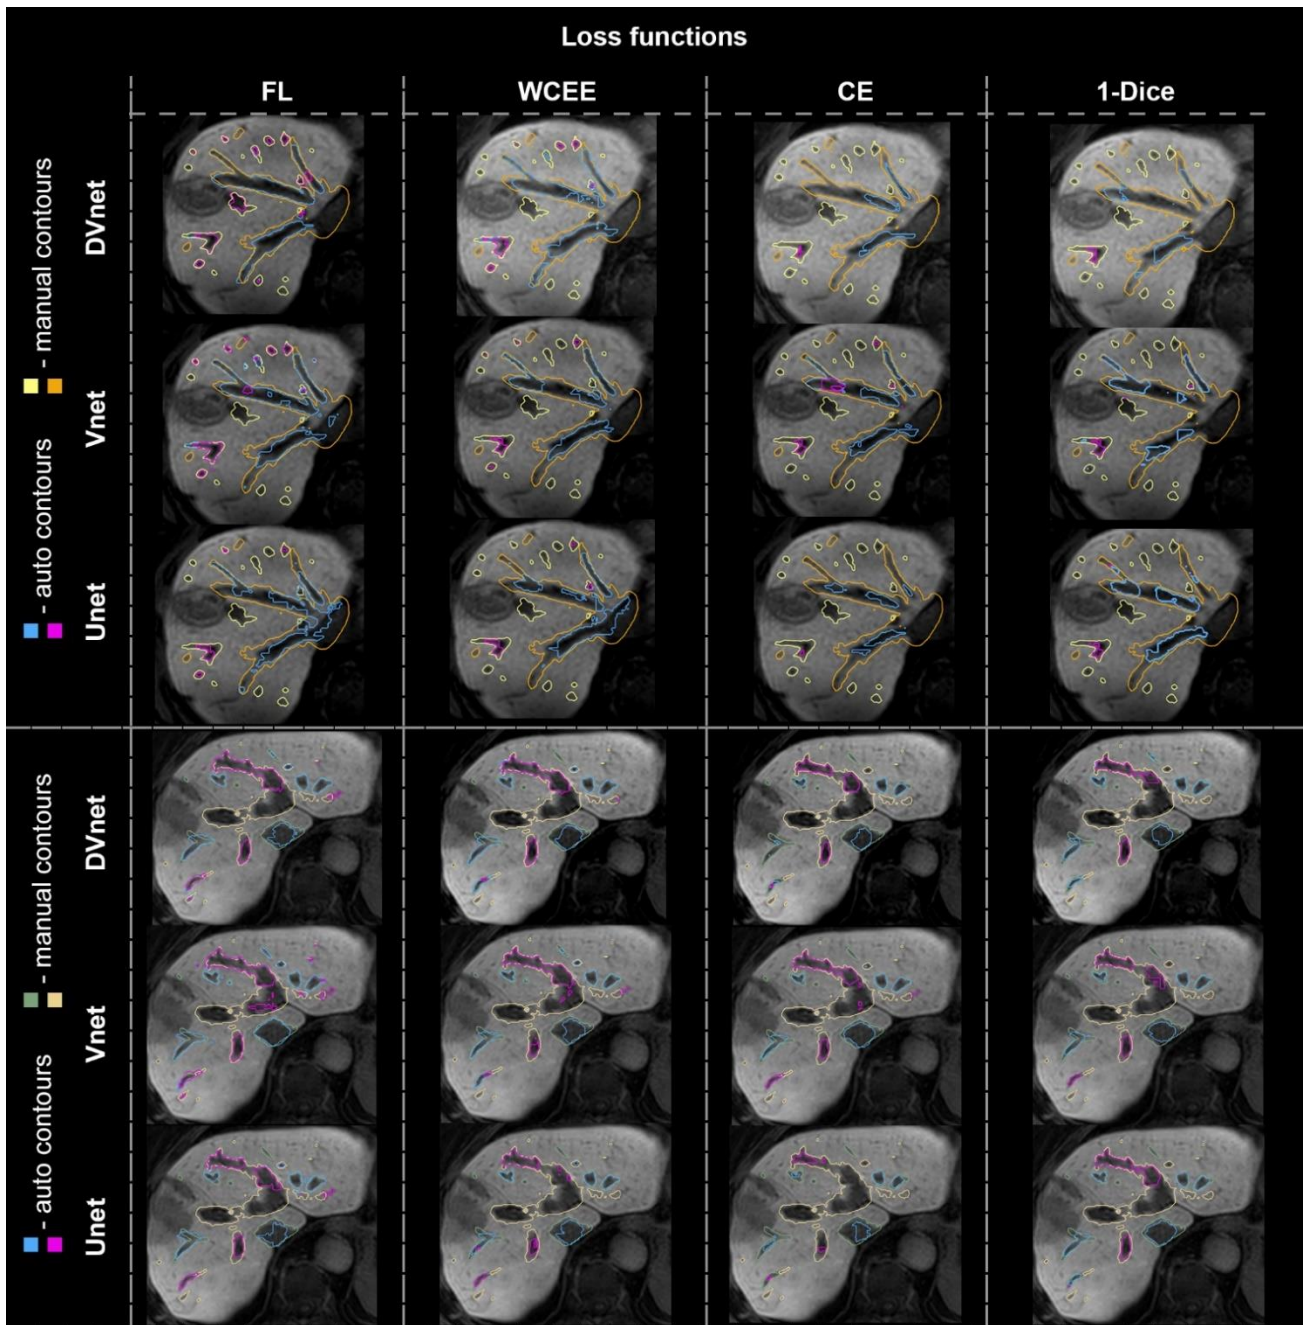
Visual comparison of final segmentation contours, achieved with each trained model, compared to the “gold standard” manual segmentations for two MRI test datasets, containing challenging anatomy of the liver (e.g., high tumor load).
